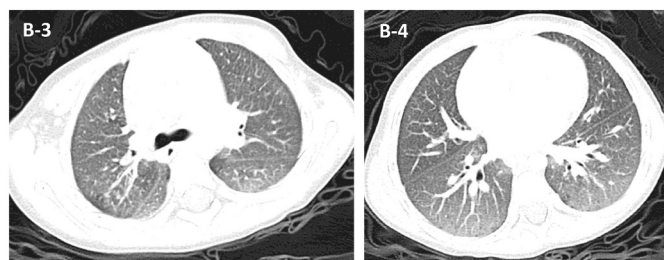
Chest CT of patient B, 1 month after lung involvement was discovered on CXR.
